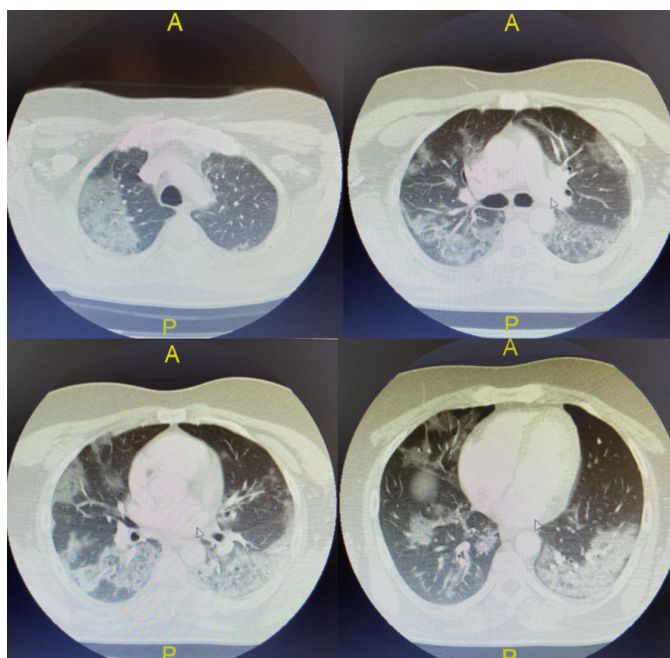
Repeated computed tomography pulmonary angiogram on 6th day of follow-up: Significant progression with approximately 50-75% of the lung parenchyma being affected
